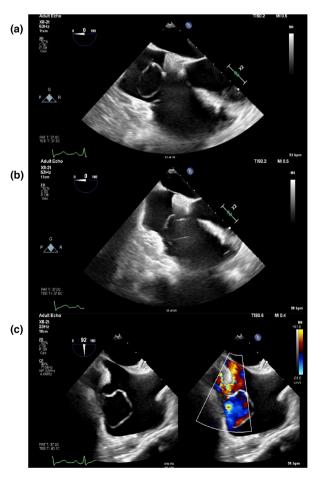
(a, b) transoesophageal echocardiography images demonstrating a 3×2 cm right atrial mass, continuous with the coronary sinus; (c) colour Doppler demonstrating flow into the right atrium.
